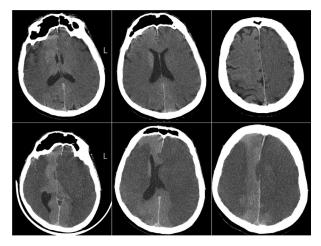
Initial (upper row)and subsequent (lower row) brain CT scans. Initial study shows bilateral mild hypodensity of both brain hemispheres, note the decrease of brain sulci predominately on the left side. Follow -up shows bilateral massive ischemic stroke in the anterior circulation. The right ischemic zone is located in the territory of the middle cerebral artery and in the left anterior and middle cerebral arteries. The midline is shifted to the left side. Only the right anterior cerebral artery and posterior circulation are preserved.
